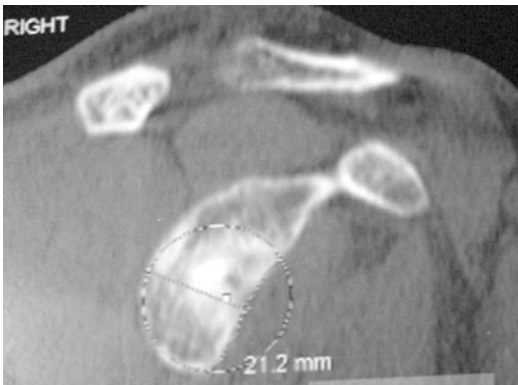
Preoperative 3D CT scan. A 23% glenoid bone loss was calculated on the en face reconstructed view of a CT scan with the humeral head eliminated according to the circle method [2]
